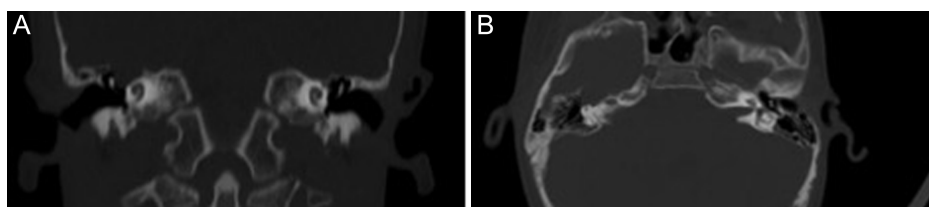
CT scan shows the mass on the right side involving the GG and the tympanic segment on the FN, in coronal (A) and axial (B) view. CT, computed tomography; GG, geniculate ganglion.
